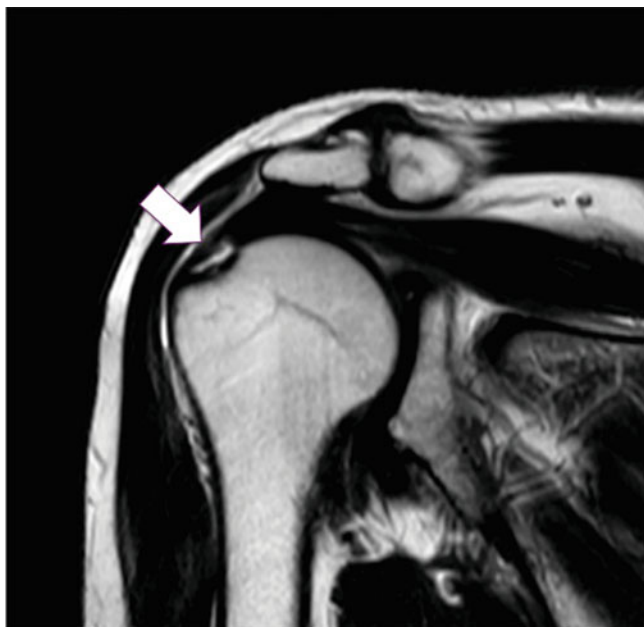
MRI image. The arrow shows a partial tear
